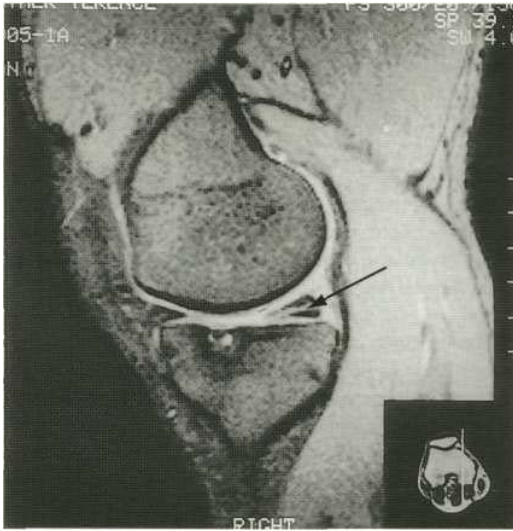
MRI of a knee, showing a complete tear of the posterior horn of the medial meniscus, extending to its lower surface (arrow).
